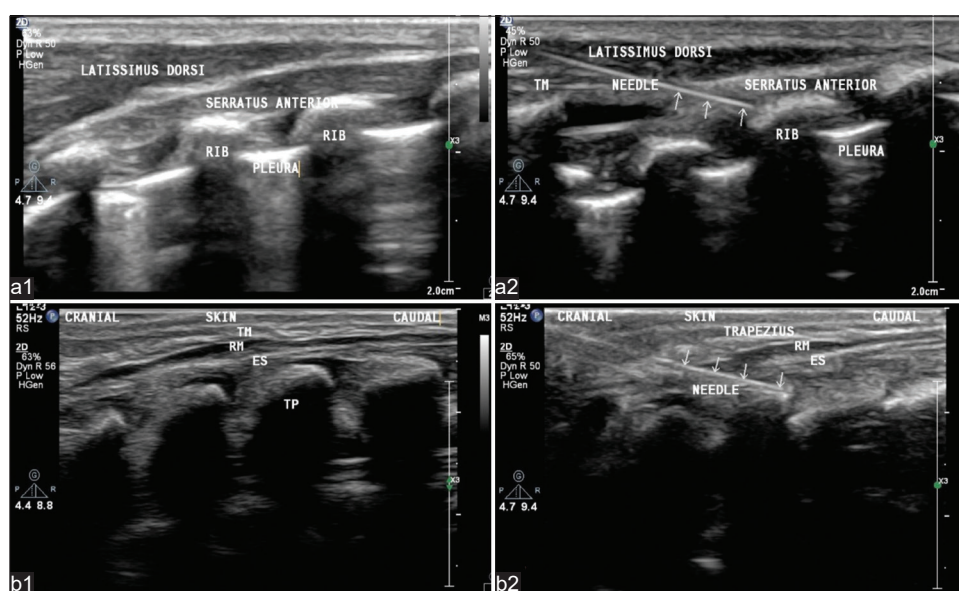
Depiction of the serratus anterior plane block sonoanatomy (a1); Ultrasonographic image with the needle directed (at the level of the fifth rib) toward the optimal plane just below the serratus anterior muscle (a2); Sonoanatomy of erector spinae plane block (b1); The in-plane needle tract and tip can be visualized below the erector spinae muscle (b2).
